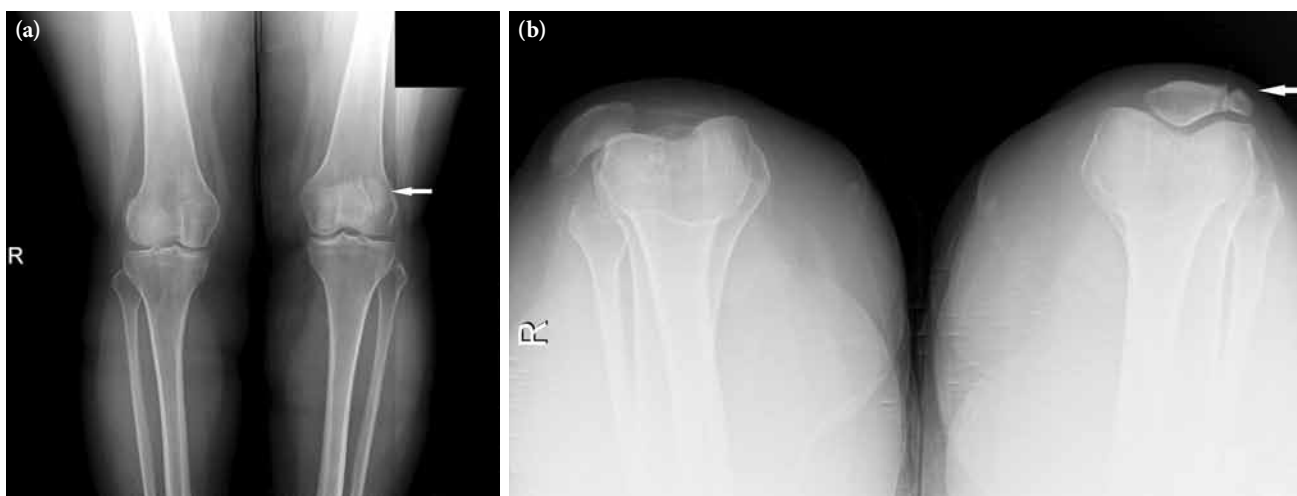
(a) Anteroposterior knee and (b) skyline patella view of both knees radiograph.
